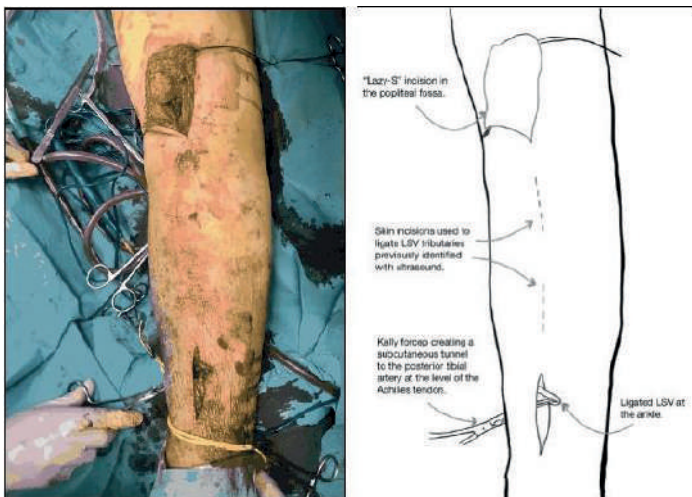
Proximal and distal exposures to control both the lesser saphenous vein (LSV) and the target arteries with the patient in prone position. In the right panel, the dashed lines represent the skin incisions used to ligate LSV tributaries identified with ultrasound after bypass anastomoses were completed.
